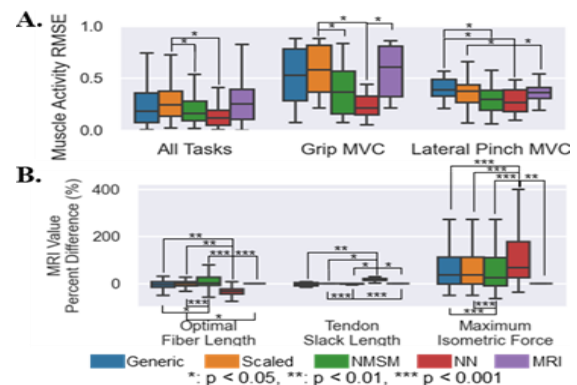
(a) Model performance predicting activations for one representative muscle (FPL) in 3 representative tasks. Averages across the 5 NN and 5 NMSM models are displayed for readability. (b) Difference between predicted and measured muscle parameters. MRI model parameters (baseline) is included as 0% to visualize significance.
